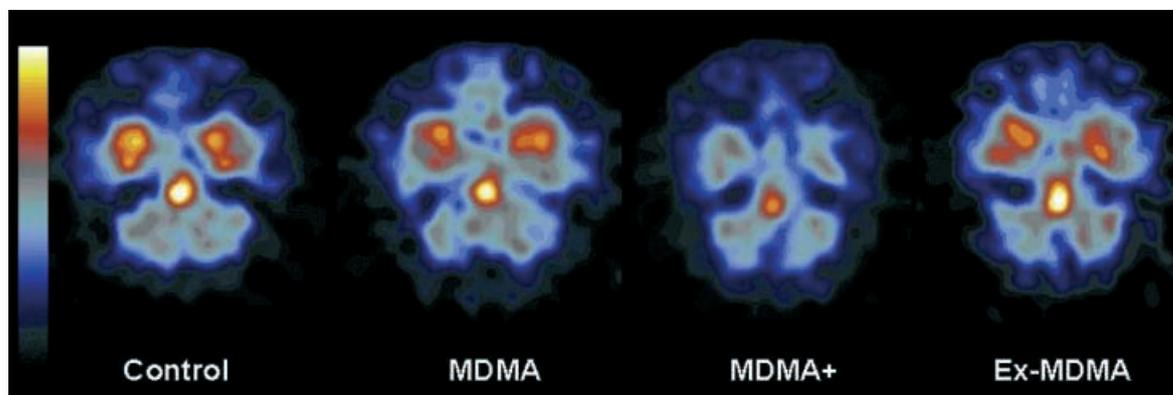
$[^{123}\text{I}]\beta\text{-CIT}$ SPECT images of a female control subject, a female moderate MDMA user (MDMA), a female heavy MDMA user (MDMA+) and a female ex-MDMA user (ex-MDMA). Transverse slices from the brain at the level of the midbrain. In the three images the level of $[^{123}\text{I}]\beta\text{-CIT}$ activity is color encoded from low (black) to high (white) and scaled to the maximum in the slice of the control subject. The images show loss of 5-HT transporters in the midbrain of a female heavy MDMA user (from Reneman et al., 2001, with permission)
